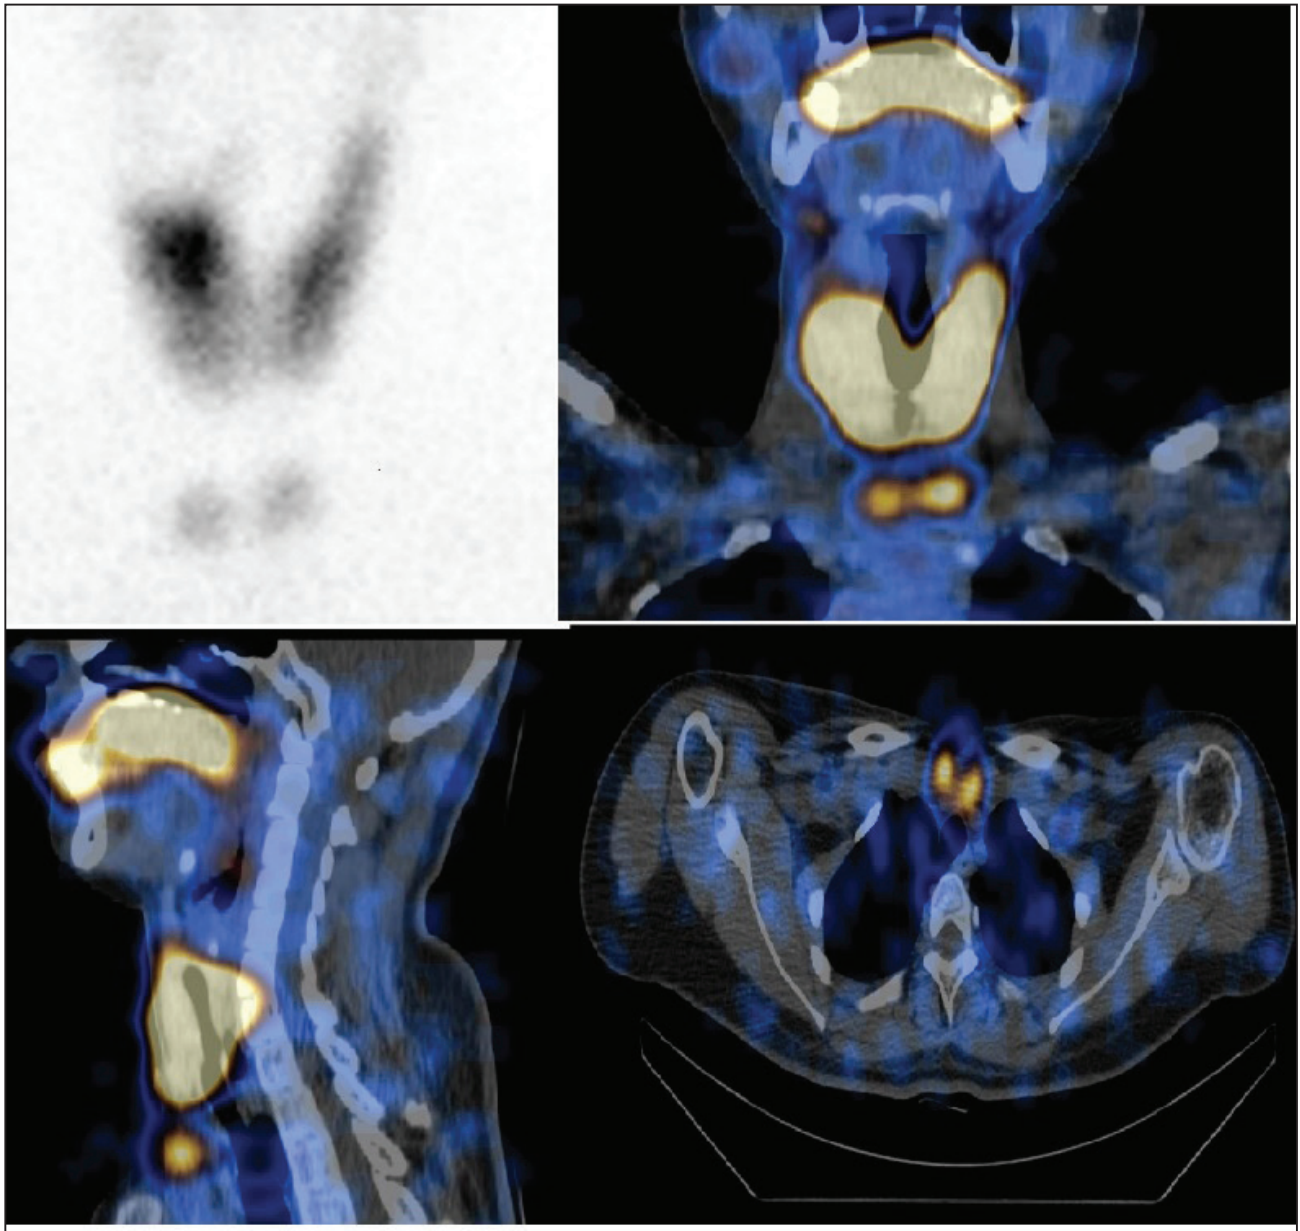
Detection of ectopic thyroid tissue in the superior mediastinum via thyroid scan and SPECT/CT imaging.
